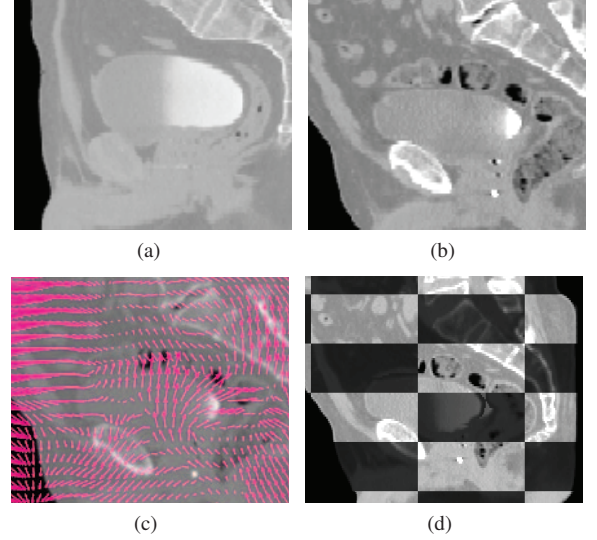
Example of registration between (a) an individual and (b) the template: (c) computed merged Deformation Field and (d) Checkerboard view between the CT of the template (light gray) and the registered CT of an individual (dark gray)
